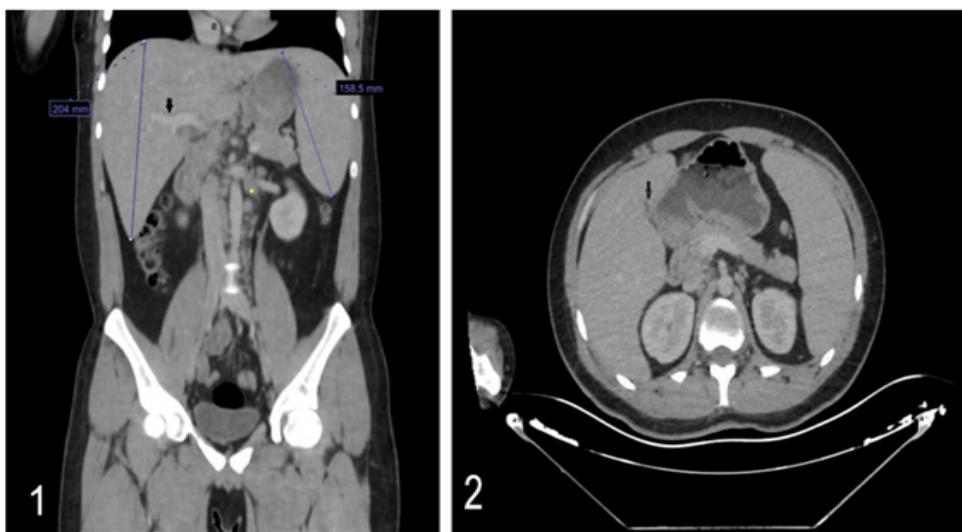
Coronal abdominal CT image shows periportal edema (arrow), increased liver and spleen size, minimal heterogeneity in the parenchyma, and multiple moderate lymphadenopathy (stars) in the mesenteric fat tissue.
